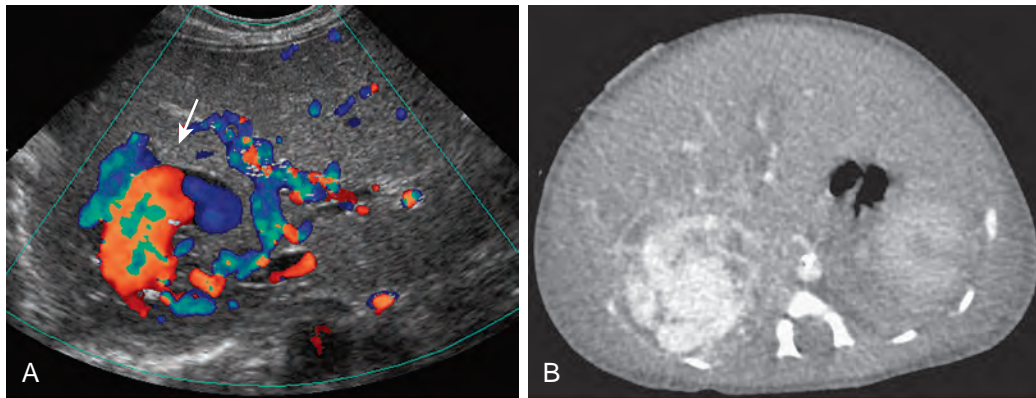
Hepatic arteriovenous malformation. A. Ultrasound of the posterior right hepatic lobe in an infant reveals a large arteriovenous malformation with direct communication between the right hepatic vein and the hepatic artery (arrow). B. On the axial contrast-enhanced CT scan of the liver in the same infant with a large arteriovenous malformation involving the posterior right hepatic lobe, notice the lack of hepatic parenchyma between the abnormal vessels.
